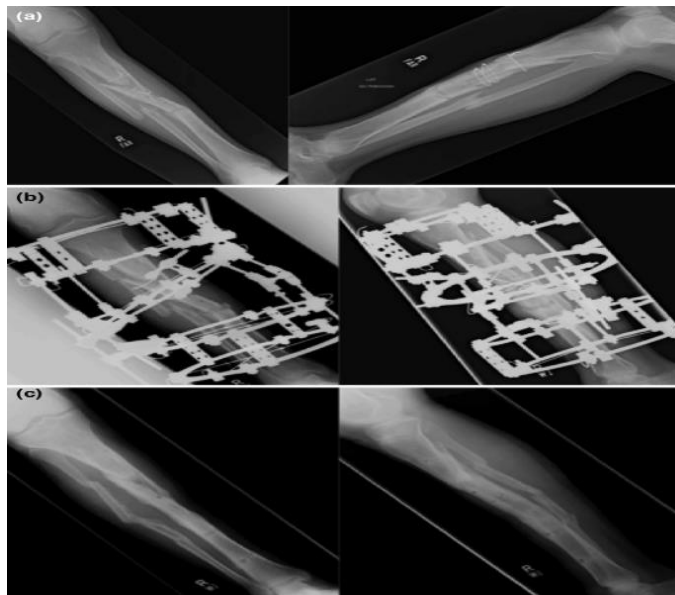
Patient 1's radiographs. (a) Anteroposterior and lateral images of the tibia before surgery demonstrate tibia nonunion. (b) Antero-posterior and lateral views following Ilizarov application. (c) Antero-posterior and lateral images at the last follow-up, demonstrating bony union.
